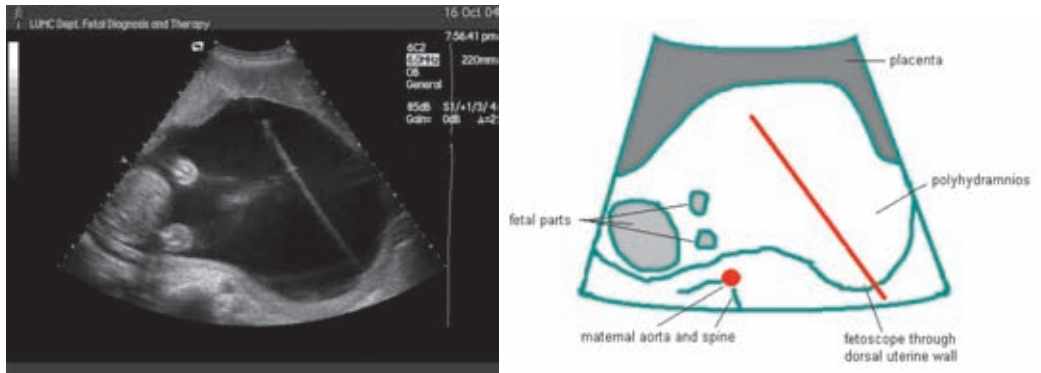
Transverse sonographic view (transducer at maternal umbilicus) of the uterus with fetoscopic entry site in the dorsal uterine wall.
